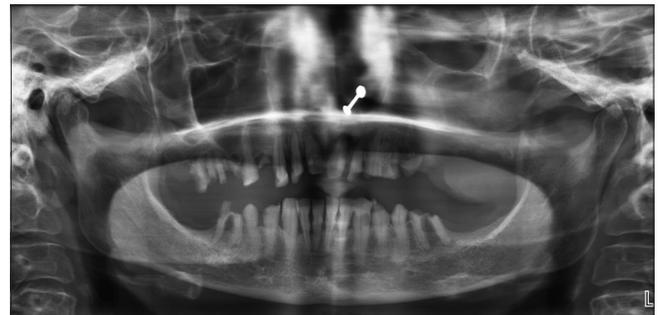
Orthopantomograph shows osteolytic area extending from distal aspect of 25 to 28 region (covered by soft tissue shadow)
